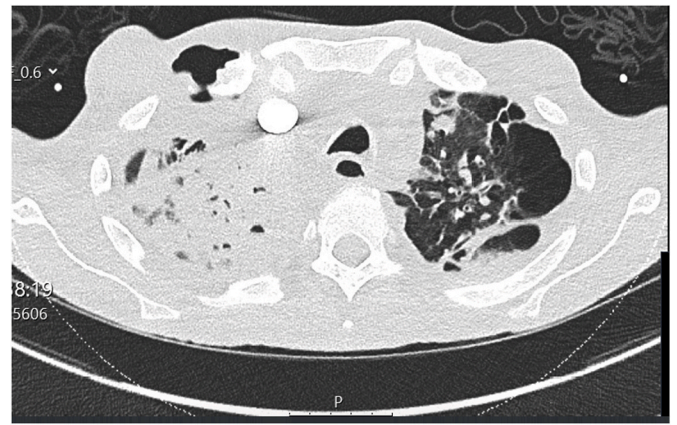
CT scan showing the defect in the right anteromedial chest wall.
